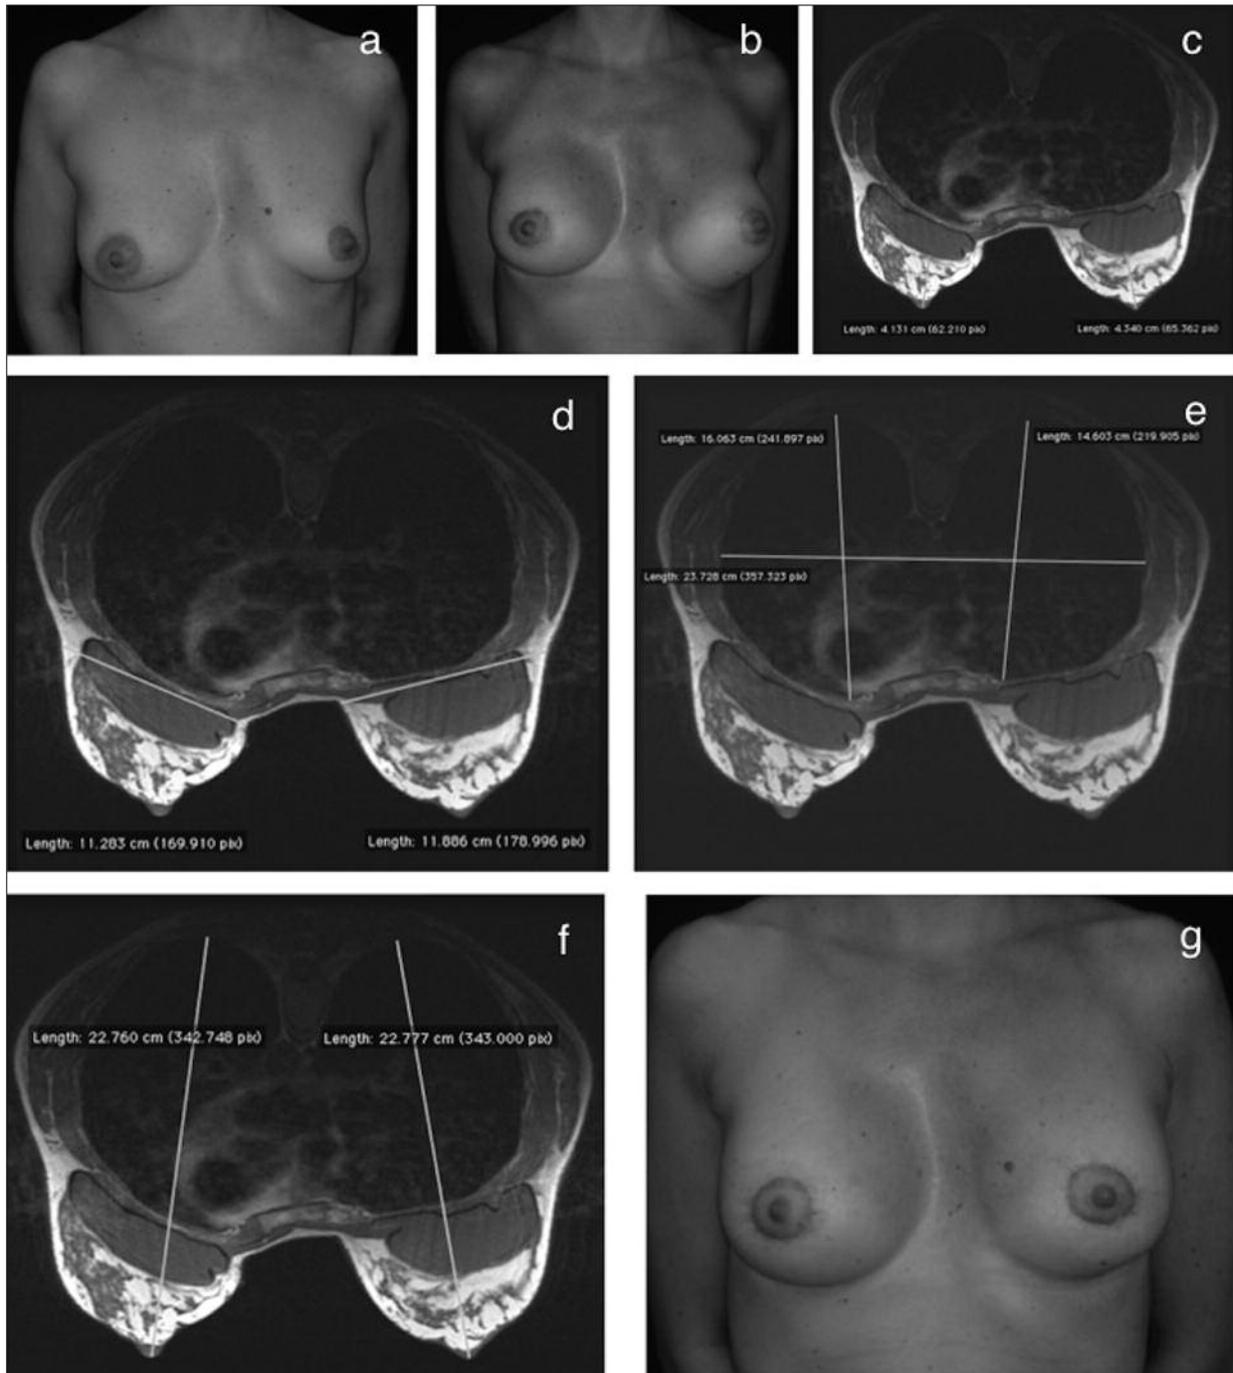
a*, Example of a patient with breast asymmetry. Preoperative photo showing breast asymmetry. *b*, Postoperative photo of the same patient. The outcome was sub-optimal: the left breast projects laterally and the left inframammary fold is more caudal compared to the right side. Corrective surgery was therefore performed after an MRI analysis of the breast and chest wall (*c, d, e, f*). Preoperative MRI measurements were helpful to customize the surgical approach. *g*, The same patient after corrective surgery: the left breast projection and the level of the left inframammary fold were corrected.
